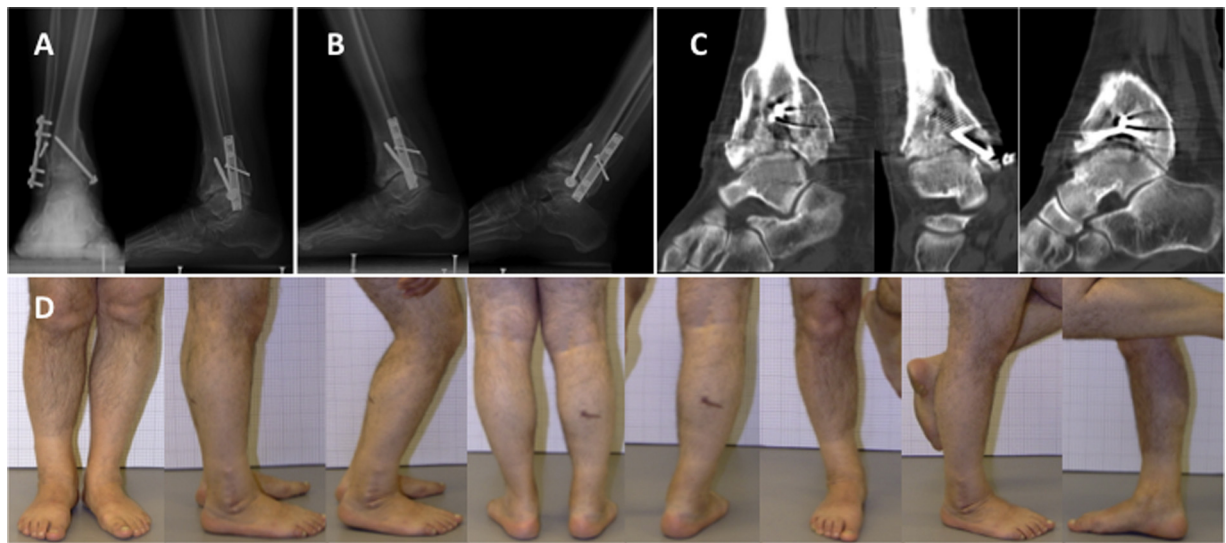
Radiological and clinical results in post-operative year 13; (A) standing anterior–posterior radiographs; (B) lateral radiographs in maximum plantar and dorsal flexion positions; (C) coronal, sagittal and axial computed tomography images of the tibiotalar joint; and (D) clinical results.
